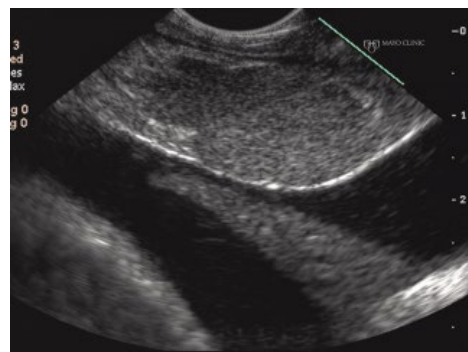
Endoscopic ultrasound image of a biopsy proven malignant lymph node.
